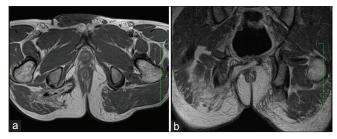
T1-weighted post-contrast axial and coronal: Transsphincteric Y shaped recto-cutaneous fistula with external opening at 7 o' clock position with right ischiorectal and gluteal abscess formation as described above
